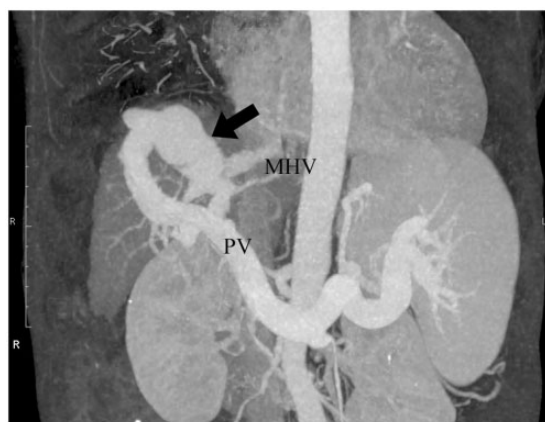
3D CT at the portal phase. 3D-CT revealed intrahepatic PSS (arrow) between the portal vein branch (PV) and the middle hepatic vein (MHV).
